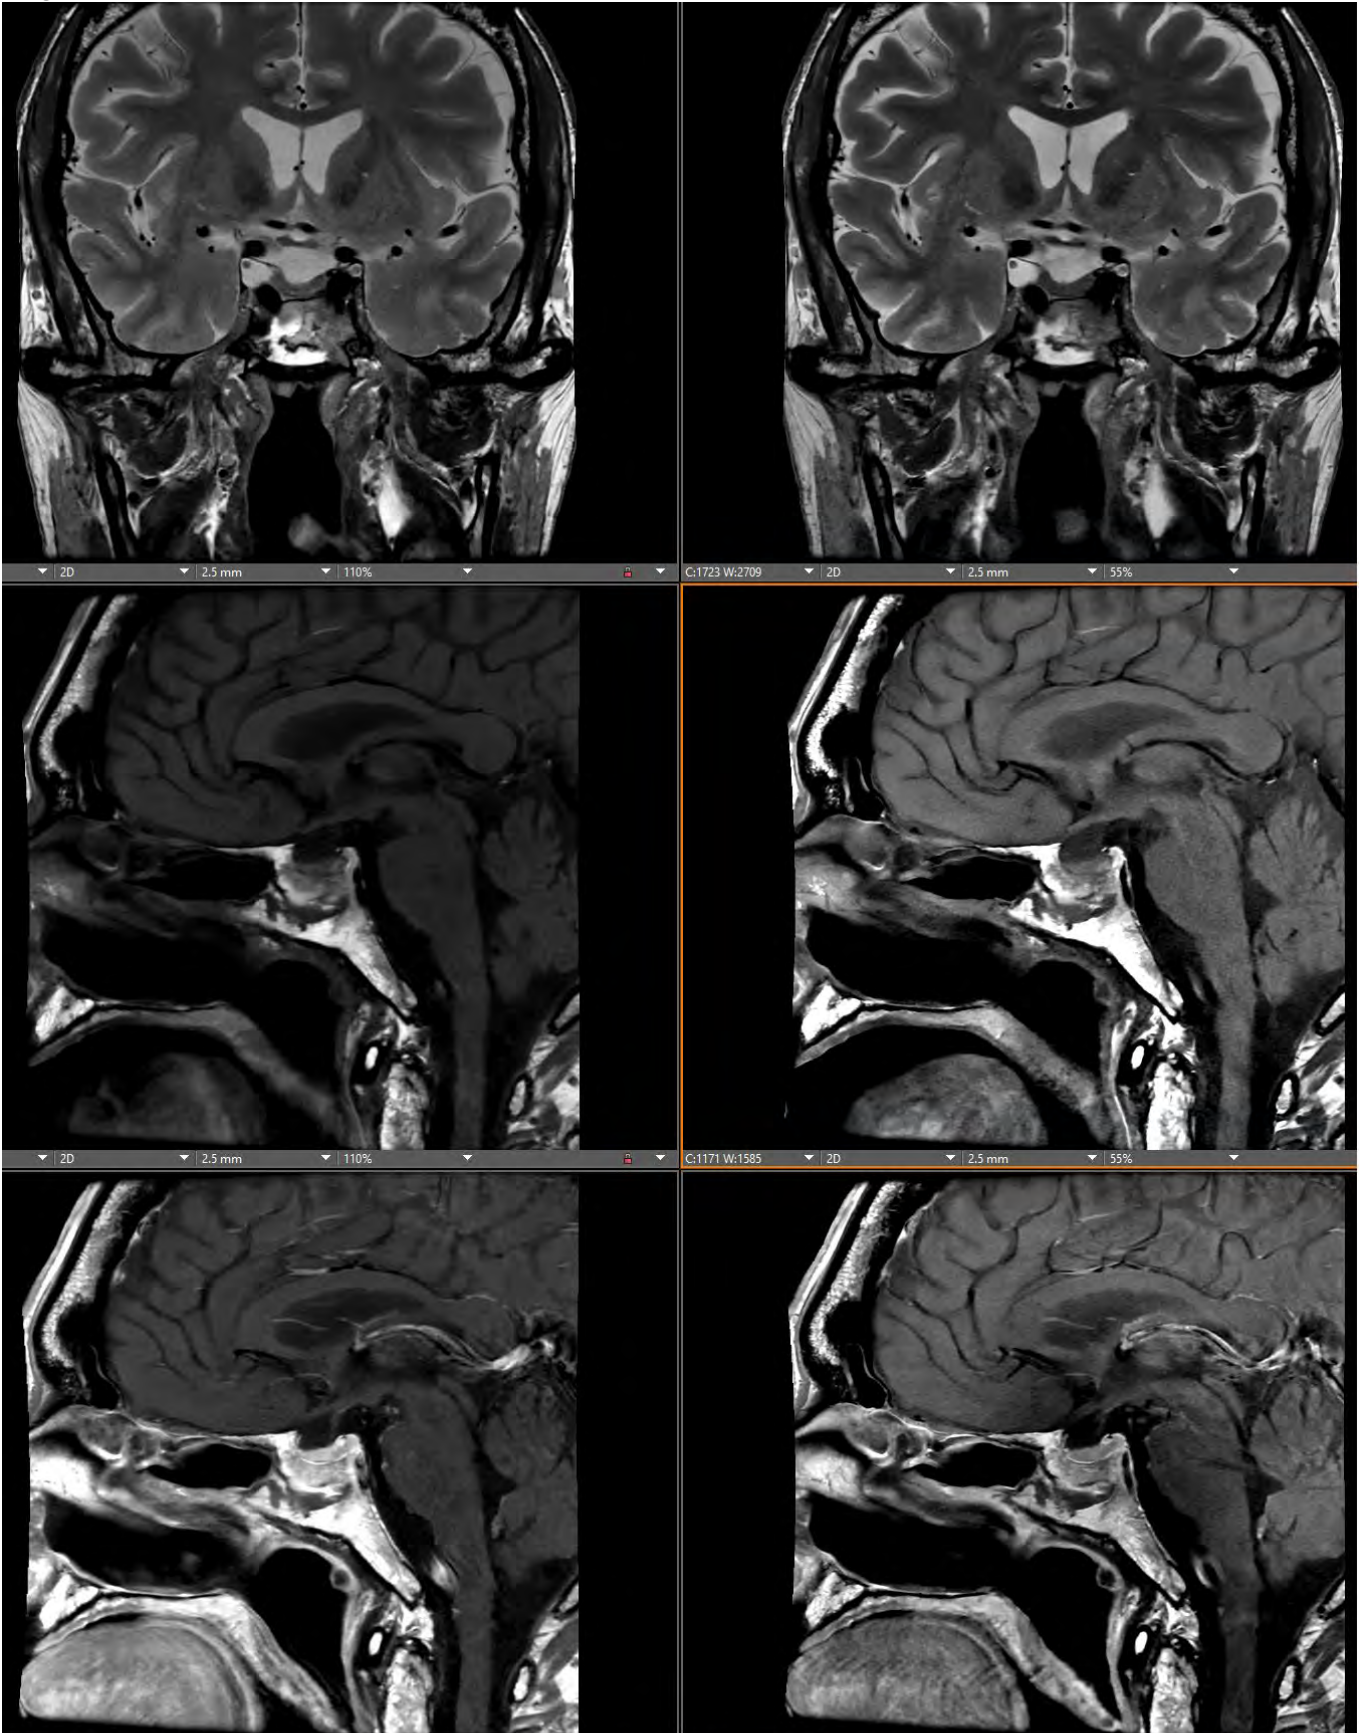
Comparison of standard and accelerated (Vortex) pituitary MRI. Representative images from the same patient demonstrating the standard acquisition versus the Vortex protocol. (A) Standard Coronal T2-weighted, (B) Vortex Coronal T2-weighted, (C) Standard Sagittal T1-weighted pre-contrast, (D) Vortex Sagittal T1-weighted pre-contrast, (E) Standard Sagittal T1-weighted post-contrast, (F) Vortex Sagittal T1-weighted post-contrast.
